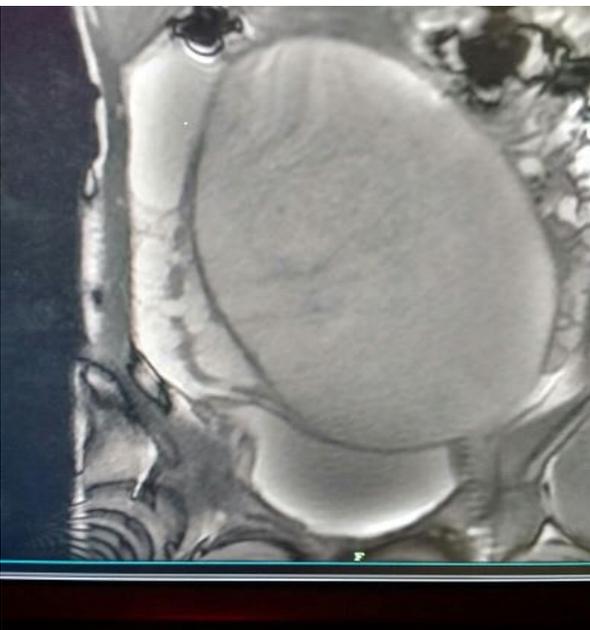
MRI image showing abdominal mass 24X20X10 cm
